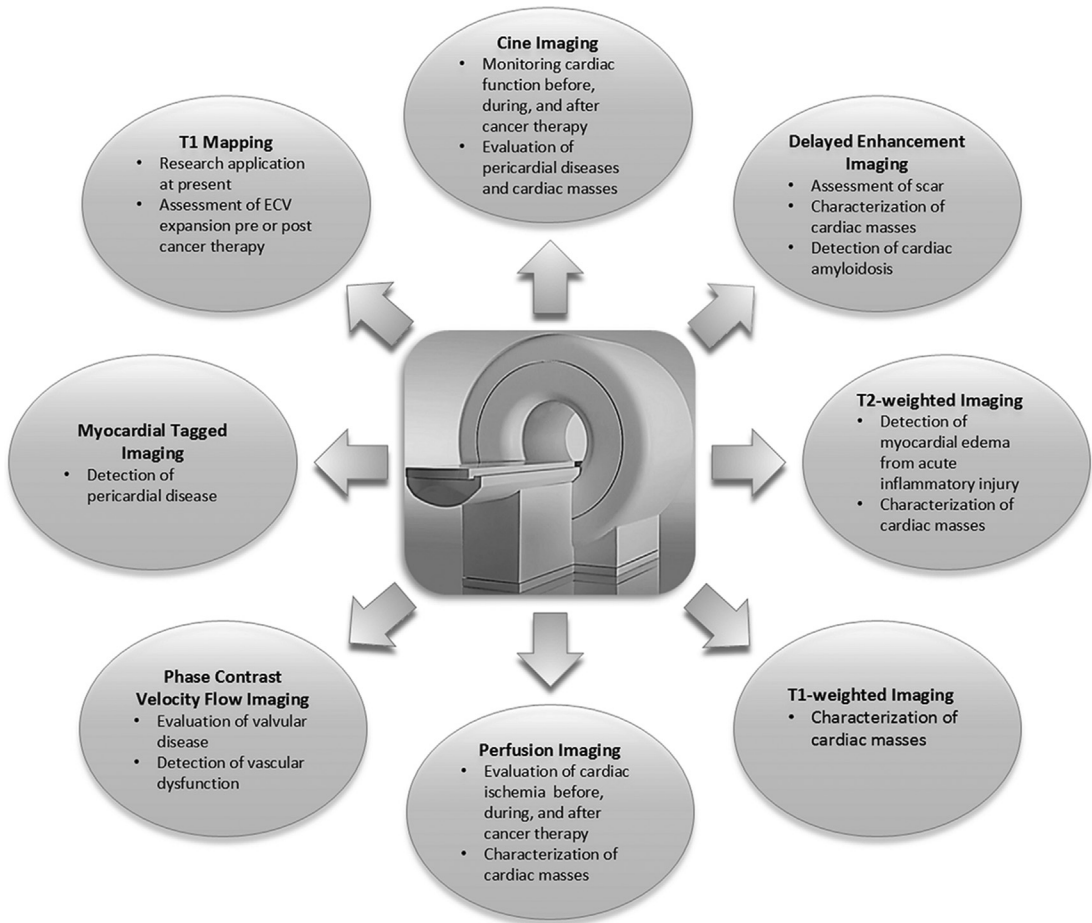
The various applications of cardiovascular MR imaging in cardio-oncology. ECV, extracellular volume.
